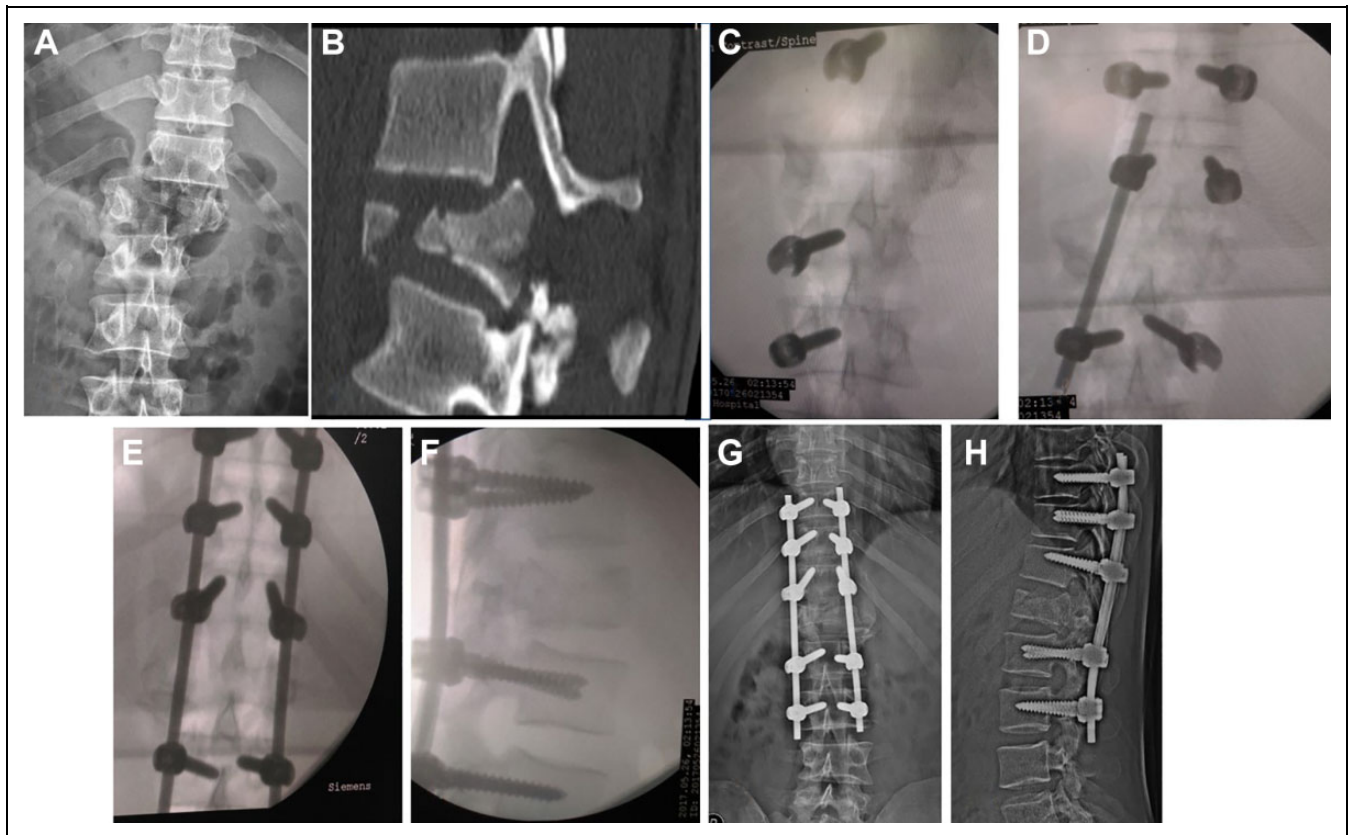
Safe surgical technique for reducing TLFD: (a) Anteroposterior radiograph and sagittal CT image (b) shows the presence of a type 3a translation. (c) Intraoperative AP image intensifier picture showing ipsilateral exposure of spine and placement of pedicle screws. (d) Image intensifier pictures shows the placement of a temporary rod for provisional stabilization and contralateral exposure to place pedicle screws 3 levels above and 2 levels below the injury. (e, f) Use of contoured rod on either side to reduce the dislocation. (g, h) Postoperative AP and lateral image shows good correction of the dislocation in both planes.
